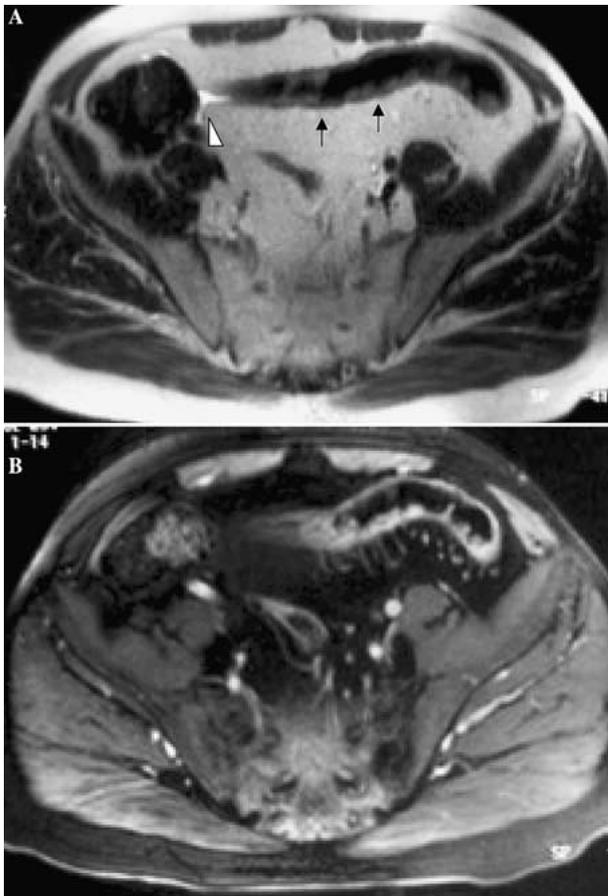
Active UC of the rectosigmoid colon. A Axial T2-weighted half-Fourier single-shot turbo spin-echo image shows diffuse wall thickening of the sigmoid colon, with a regular outer profile and a waved inner profile (*arrows*), signs that are characteristic of UC. The waved inner profile suggests the presence of inflammatory pseudopolyps. A minimal amount of free fluid (*arrowheads*) and a possible adhesion to the medial cecal wall are evident on the right side. Active disease was diagnosed at the level of the entire sigmoid colon. B Axial T1-weighted fast low-angle single-shot post-gadolinium image shows similar morphologic changes with diffuse wall enhancement at the level of the sigmoid colon, suggesting active disease (printed with permission from Springer-Verlag, p. 211 [3]).
